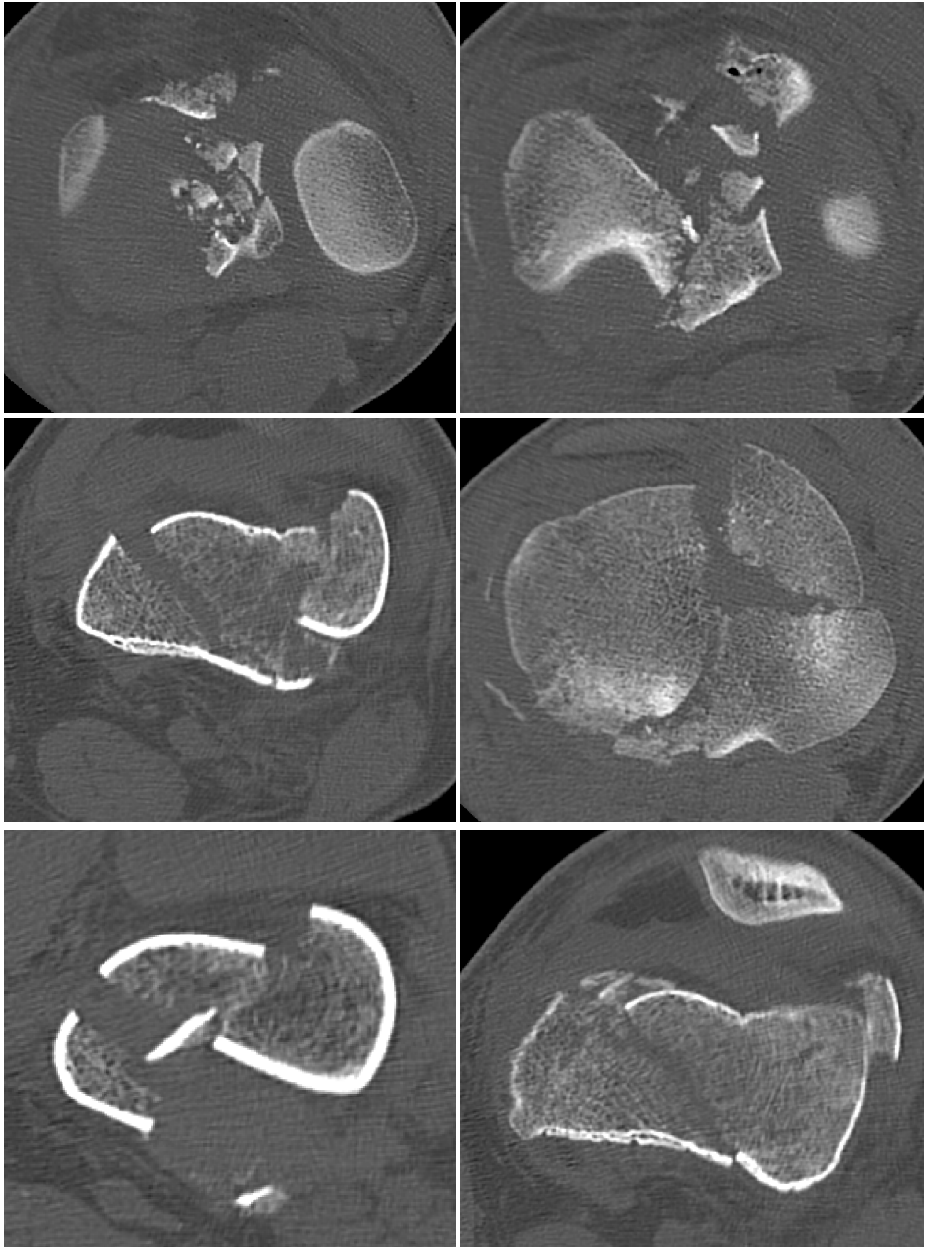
CT images representing highly comminuted bone fractures.
